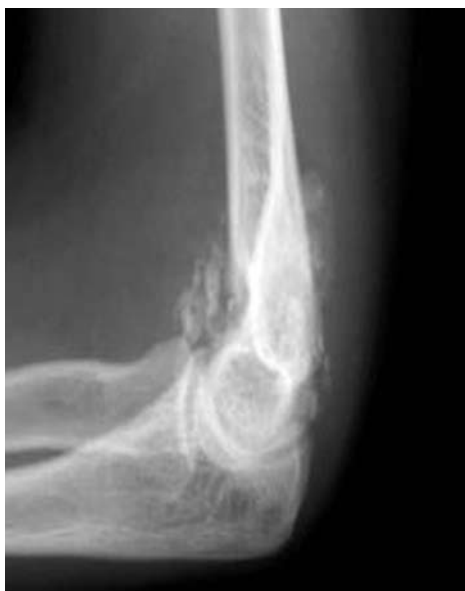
Lateral elbow radiograph of a 26-year-old woman with synovial osteochondromatosis shows many ossified rounded and stippled loose bodies around the elbow joint.
